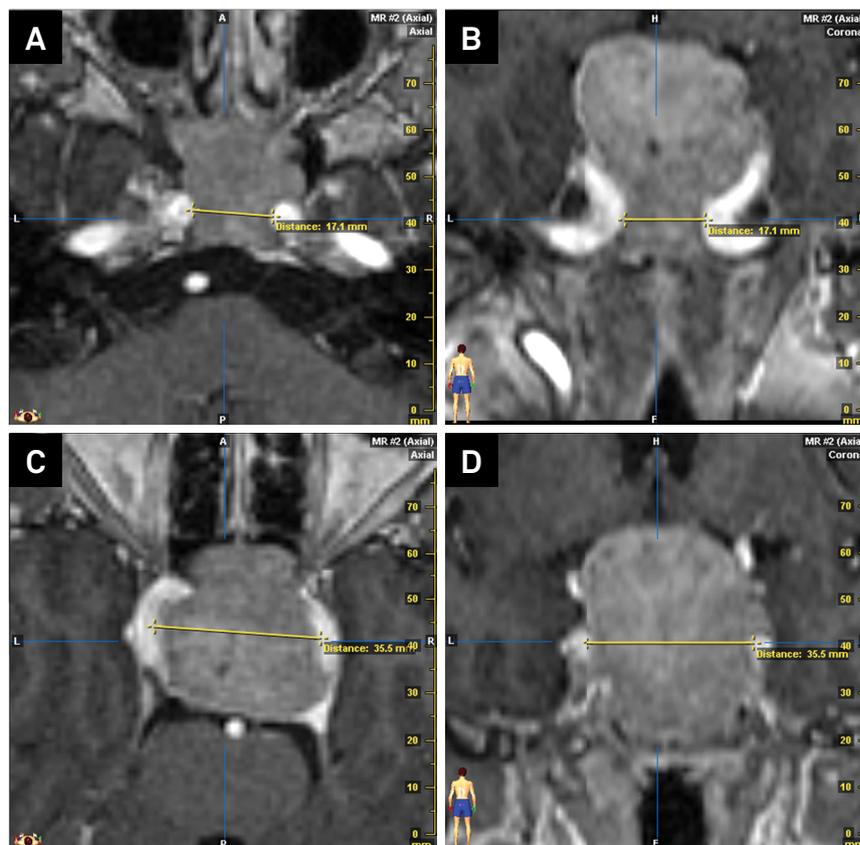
T1-weighted MRI of the sellar and parasellar regions in a patient with pituitary adenoma. (A) and (B) intercarotid distance 1 (ICD1) measured in axial and coronal plane. (C) and (D) intercarotid distance 2 (ICD2) measured in axial and coronal plane.
